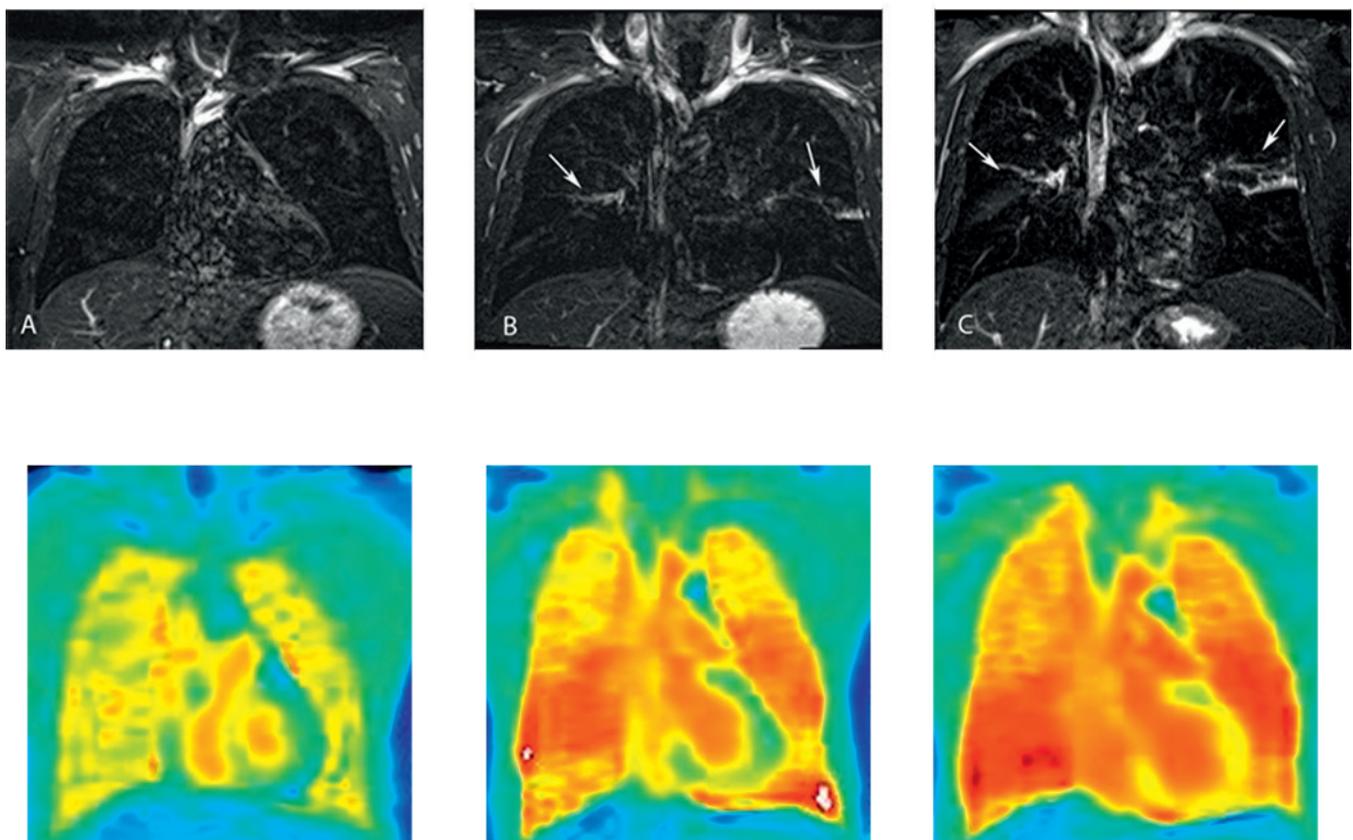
Magnetic resonance imaging of local inflammatory changes in a patient with asthma before (left images) as well as 6 hours (middle images) and 24 hours (right images) after segmental allergen challenge. Upper panels show a TIRM sequence (Turbo-Inversion Recovery-Magnitude magnetic resonance imaging). The lower panels display T1-weighted intensity maps of oxygen transfer function. MRI changes correlate closely with cellular markers of inflammation in bronchoalveolar lavage.
